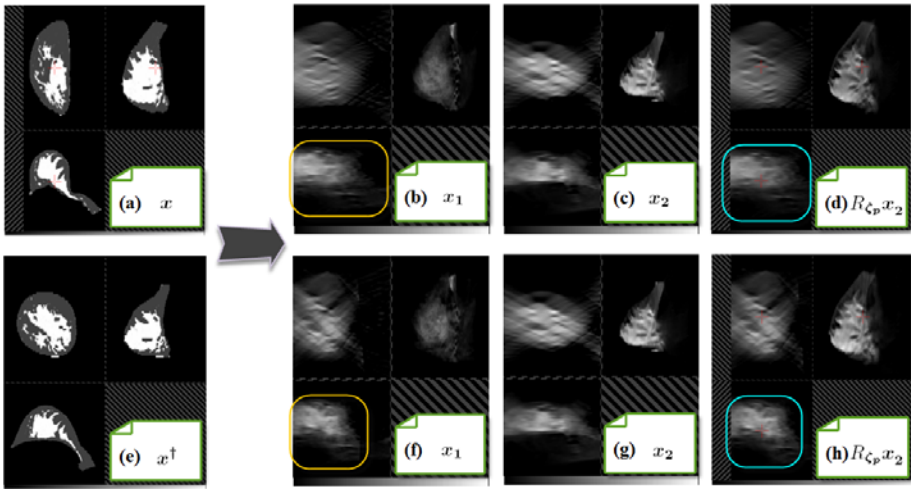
As Fig. 1 but applied to in vivo MRI acquisition of a breast before and after plate compression (Images have been segmented and mapped to effective X-ray attenuation)
